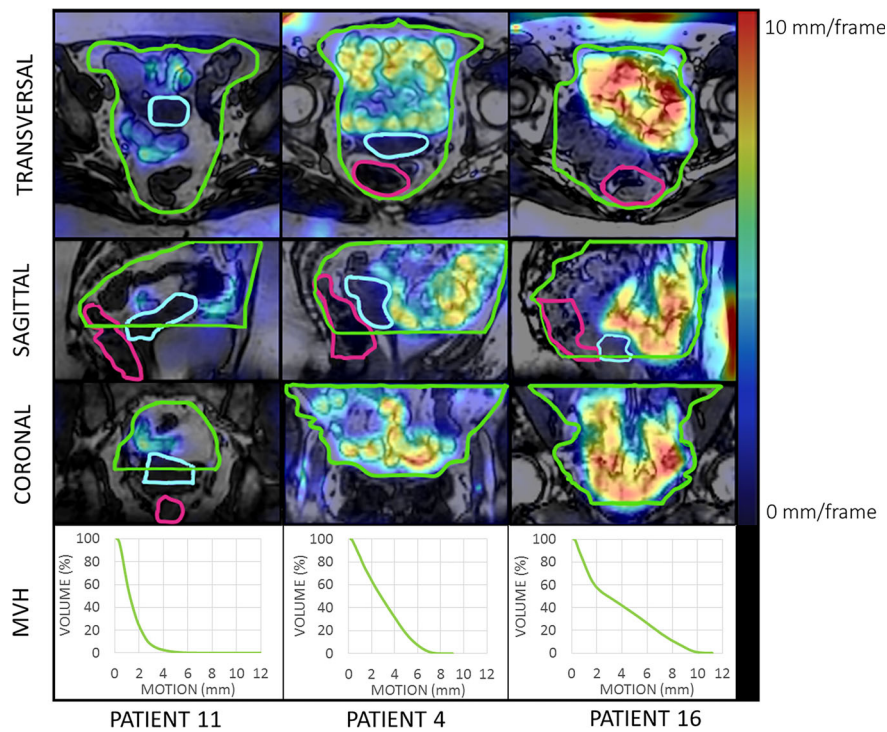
An example of three patients of the bowel motion maps and its corresponding motion–volume histogram (MVH) of the bowel bag volume (green delineation) excluding the uterus (turquoise delineation) and rectum (pink delineation) volumes. Bowel motion is defined as the mean motion per frame (3.7 s) over the 10-min acquisition, superimposed on an MRI. Red denotes high motion up to 10 mm per frame and blue denotes low motion: the more red the motion map colors, the more mobile was the bowel at that point. [Color figure can be viewed at [wileyonlinelibrary.com](#)]
